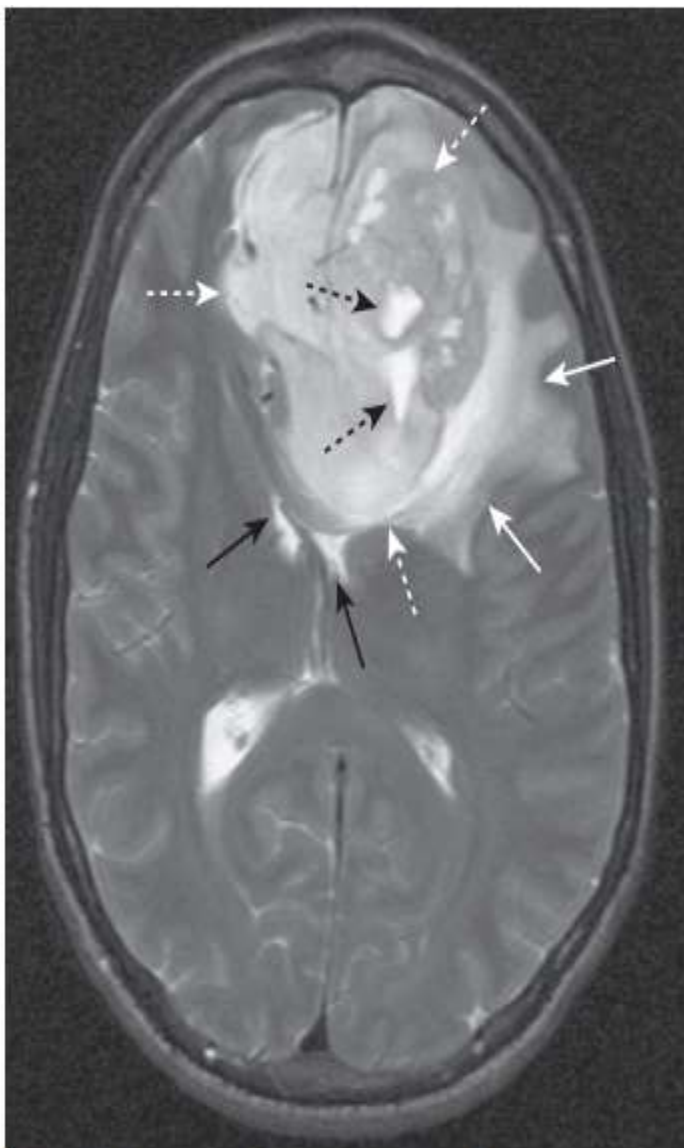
Glioblastoma multiforme with surrounding edema. Axial T2-weighted image demonstrates bright vasogenic-type edema (*solid white arrows*) surrounding a large, lobulated fronto-lobular mass (*dotted white arrows*), representing glioblastoma multiforme, an aggressive brain tumor. There are a few bright areas of cystic degeneration (*dotted black arrows*) within this mass. The frontal horns of the lateral ventricles are compressed (*solid black arrows*).
